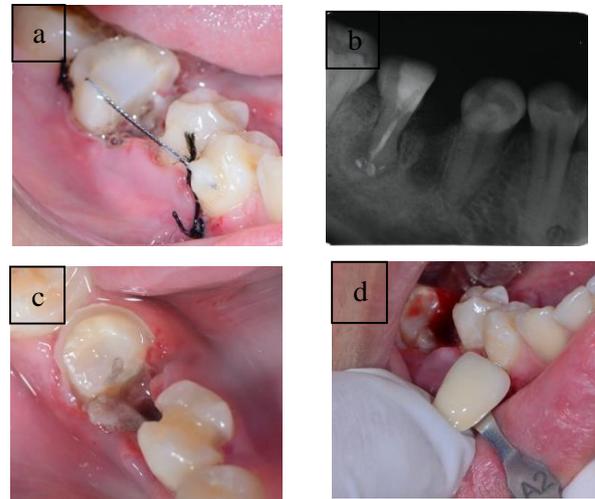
(a) temporary splinting, (b) radiographic view of 1 week after hemisection, (c) clinical view of core preparation of tooth 46 and 45, (d) adjusting color with shade guide.
